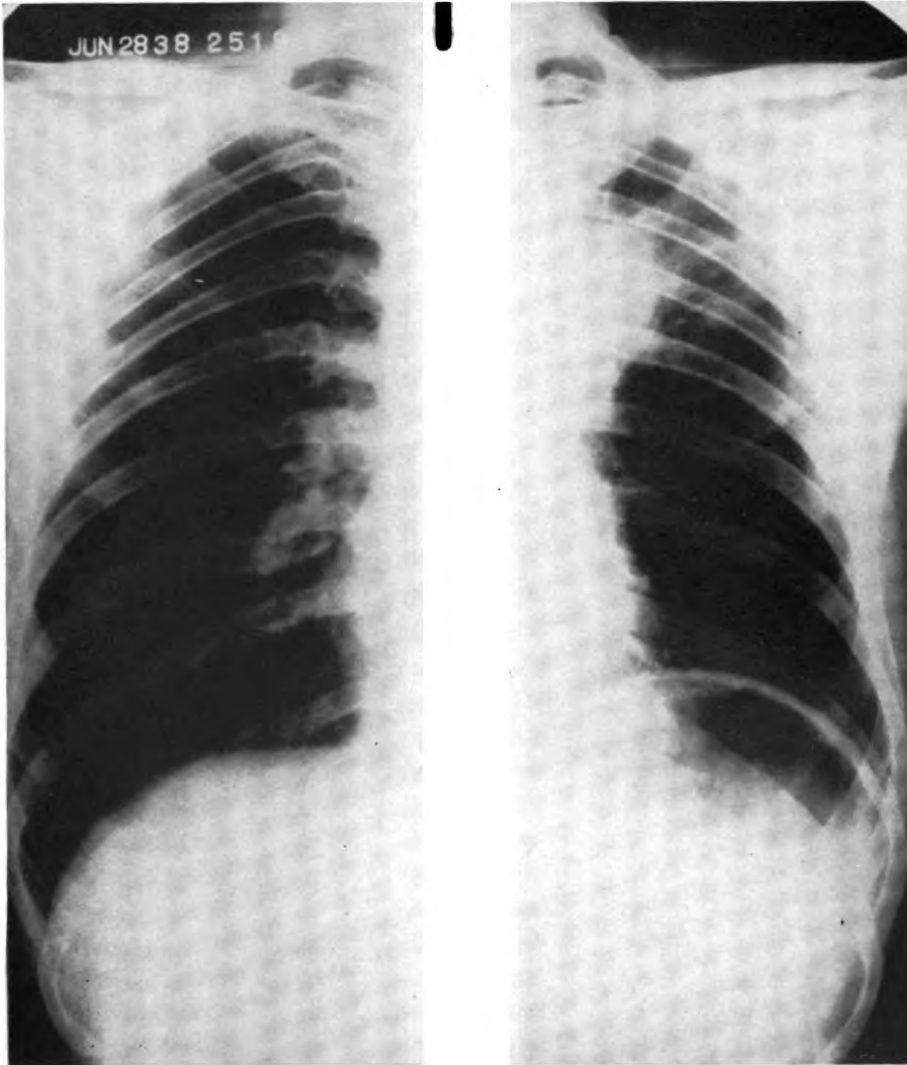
CASE 14, E. W. TUMOR NODULE MORE APPARENT AFTER ROENTGEN THERAPY.
